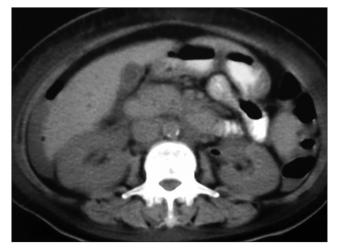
CT scan showing gas within the pelvis of left kidney (Class I EPN)
